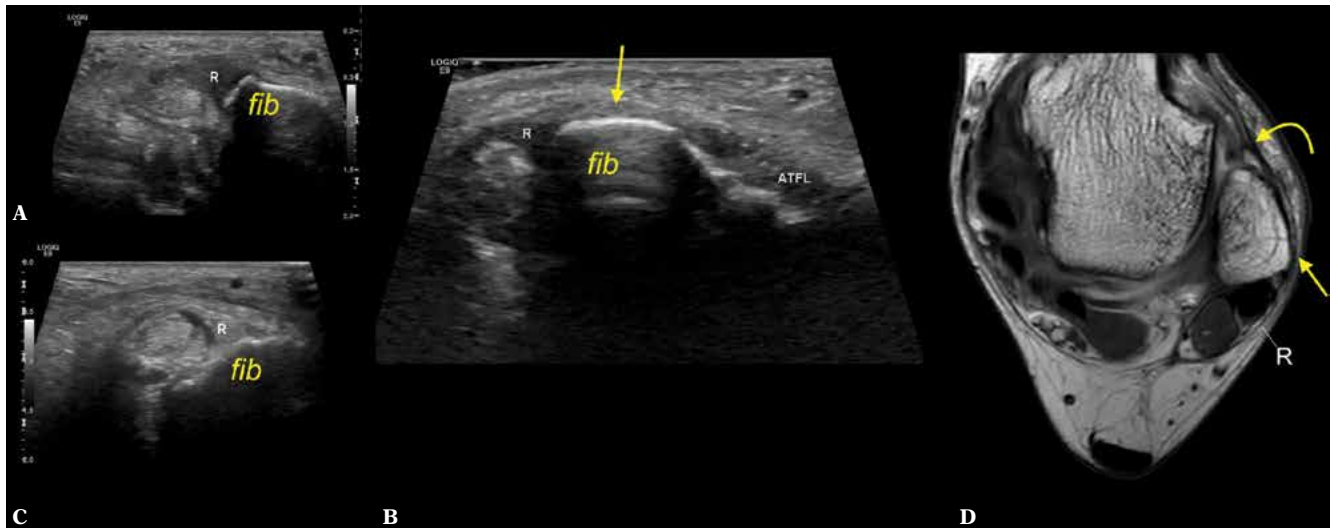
A 52-year-old patient presented with retromalleolar pain. A, B, C. transverse section on ultrasound. D. proton density-weighted transverse section. The interconnection (arrows) between the SPR (letter R) and IER (curved arrow) and ATFL. Fib – fibula
